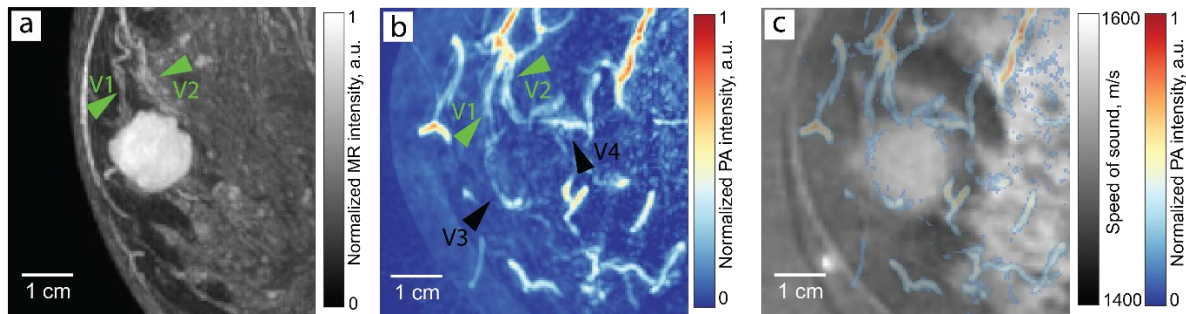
Comparison of ceMR, PA and SOS images of the analyzed patient case. (a) The local maximum intensity projection (coronal view) of a 5 mm thick slab of tissue centered in the tumor of the T1w post contrast MR image shows an enhanced mass with regular margins and the presence of associated vasculature (V1 and V2, green arrows). (b) Local maximum intensity projection of the PA image at 720 nm shows the same associated vascular structures present in MR (V1 and V2, green arrows) and also capsular vessels surrounding the fibroadenoma (V3 and V4, black arrows). (c) The central slice of the SOS map shows higher SOS value than adipose tissue in the region but does not clearly show the shape of the lesion. (d) The overlay of PA and SOS can potentially show both morphological and functional information about the lesion.
